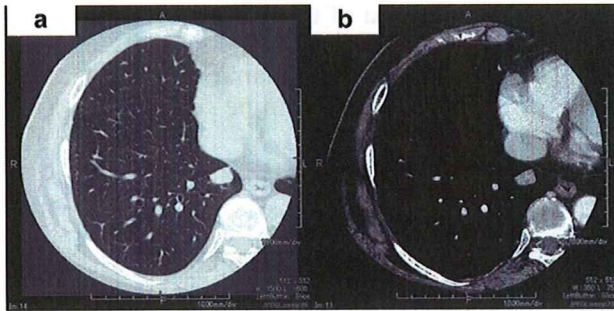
Chest computed tomography shows a 16 mm nodule in the right lower lobe.
